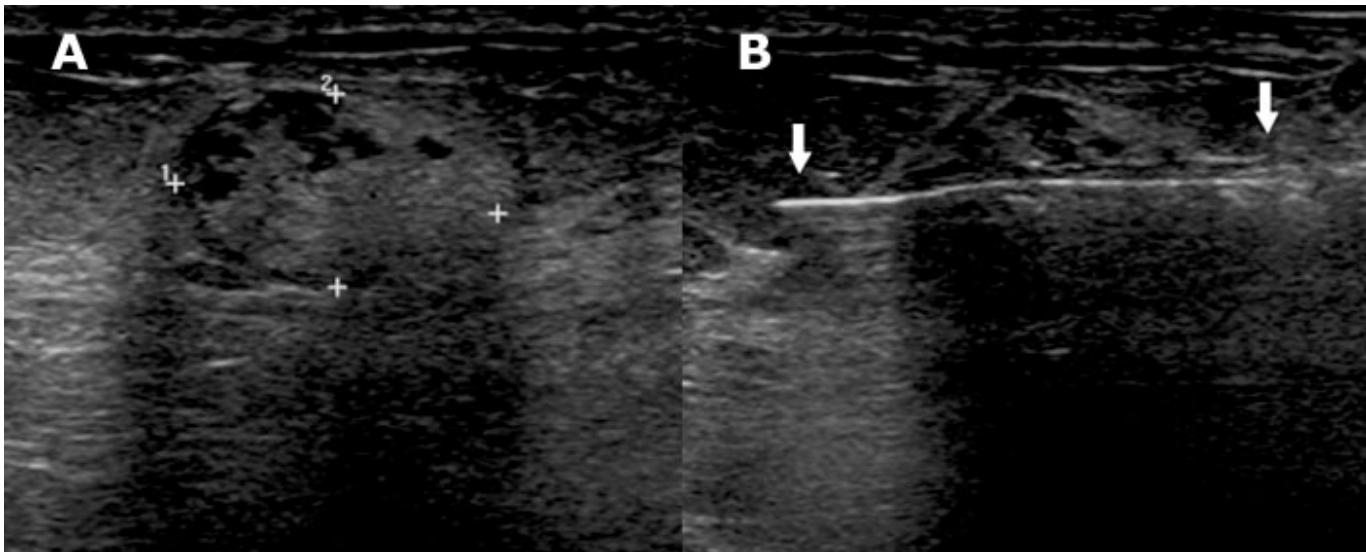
Ultrasound-guided biopsy of breast lesion. The diagnostic study (A) shows a solid lesion (calipers) suspicious for cancer. An image during the biopsy (B) shows the core biopsy needle (arrows) sampling the lesion.
